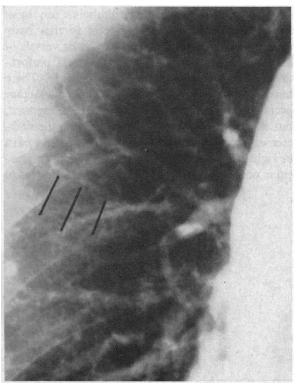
(Case 7) Pulmonary angiogram, the catheter fragment was not seen on plain films. On angiographic study it appeared as a linear, non-branching filling defect within a right pulmonary artery branch.
